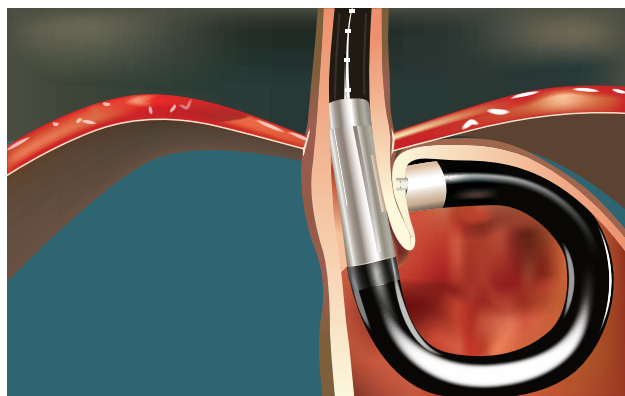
Medigus Ultrasonic Surgical Endostapler. MUSE device utilizing ultrasound to align gastric tissue and esophagus 1–3 cm proximal to the gastroesophageal junction. This is done via a single endoscope (in contrast to EsophyX, which requires the device and a second endoscope for visualization).
